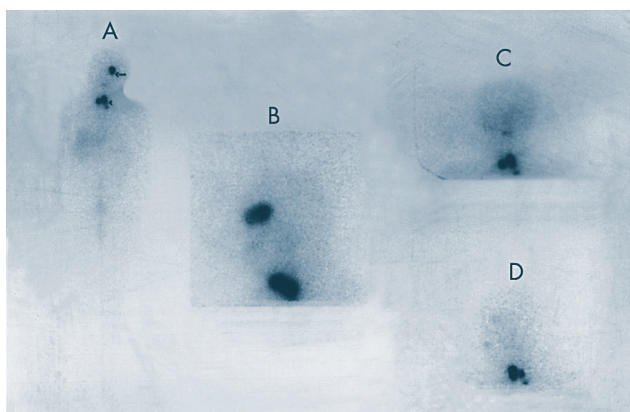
Whole body scintigraphy (A) and lateral cranial static images (B) obtained 5 days after the therapeutic dose of ^{131}I revealed three areas of focal increased uptake in the thyroid bed compatible with residual thyroid tissues (arrow head), and a focal uptake in the left orbit (arrow). Two days later, after the removing of the ocular prosthesis and cleansing of the face periodically, ^{131}I uptake in the left orbit was disappeared on anterior (C) and lateral cranial static images (D).
